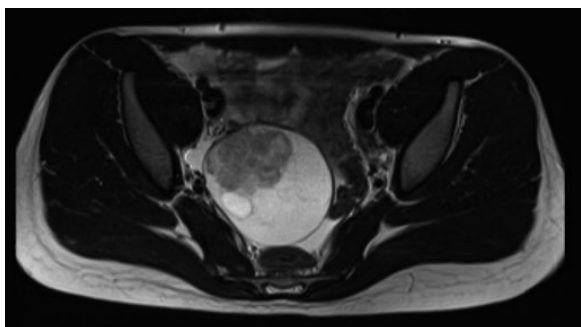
Pre-operative magnetic resonance imaging with contrast (Axial plane)
